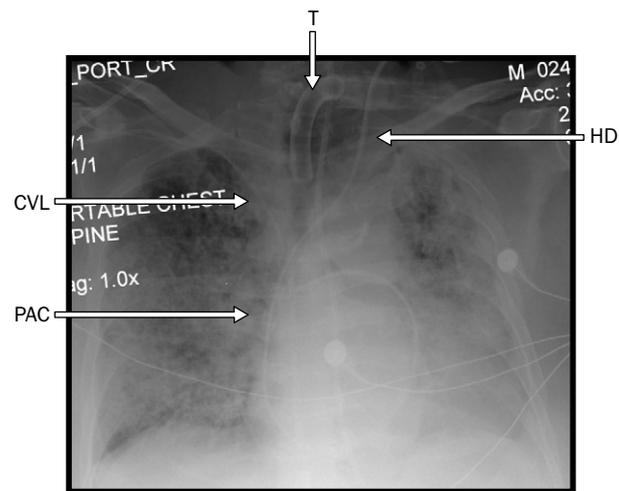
Mr B's portable chest radiograph shows bilateral fluffy infiltrates, compatible with acute respiratory distress syndrome, and both non-infectious and infectious causes of fever. In addition, he has multiple invasive devices, all of which serve as potential sources of infection. T=tracheotomy tube, HD=haemodialysis catheter, CVL=central venous line, PAC=pulmonary artery catheter
